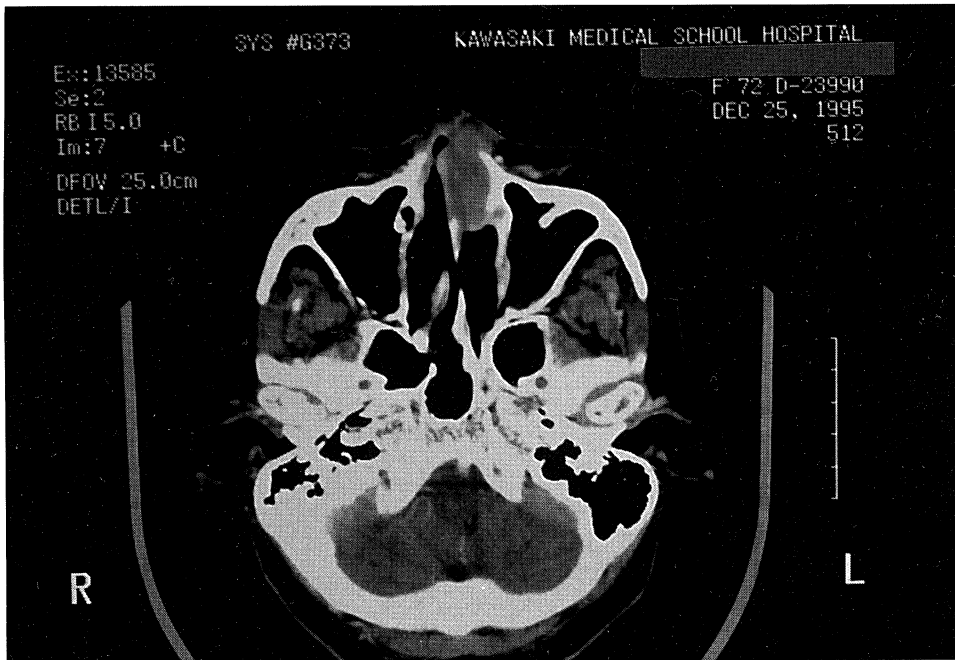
Enhanced computed tomographic scans showed a large mass in the left nasal cavity.
